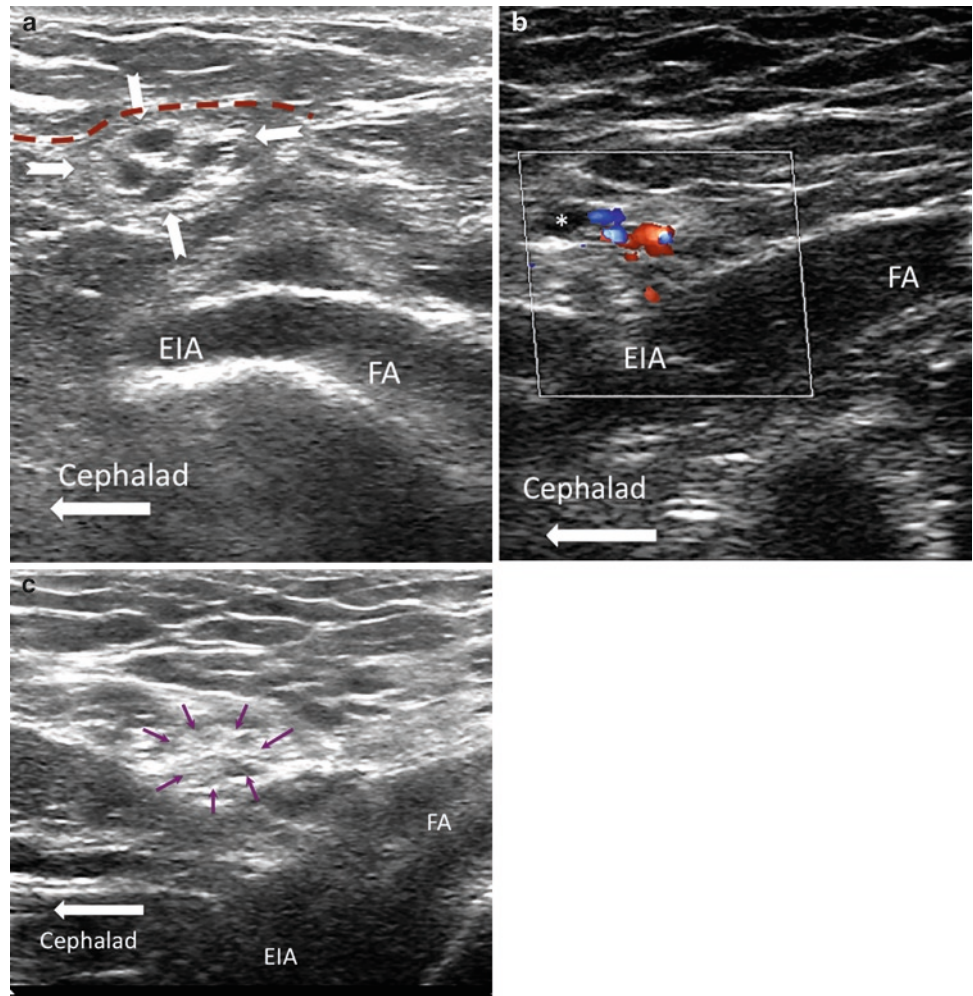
(a) Long-axis view of the femoral and external iliac artery showing the cross section of spermatic cord (outlined by *solid arrows*) in a male patient. The *red dashed line* outlines the deep abdominal fascia. (b) Similar view as (a) with color Doppler showing the vessels inside the spermatic cord. (c) Similar view as (a) but in a female patient showing the round ligament of uterus (outlined by *line arrows*). EIA external iliac artery, FA femoral artery. Reproduced with permission from USRA (www.usra.ca).
